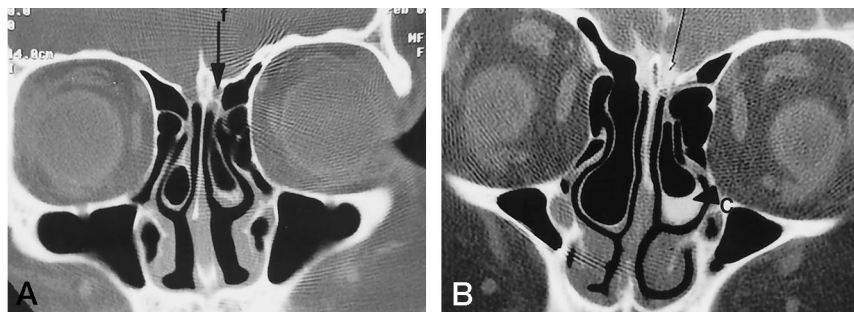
A, Plain high-resolution coronal CT scan, 1-mm thick, through the cribriform plate reveals a bone defect in the left cribriform plate (arrow) with a CSF-density column extending extracranially.
